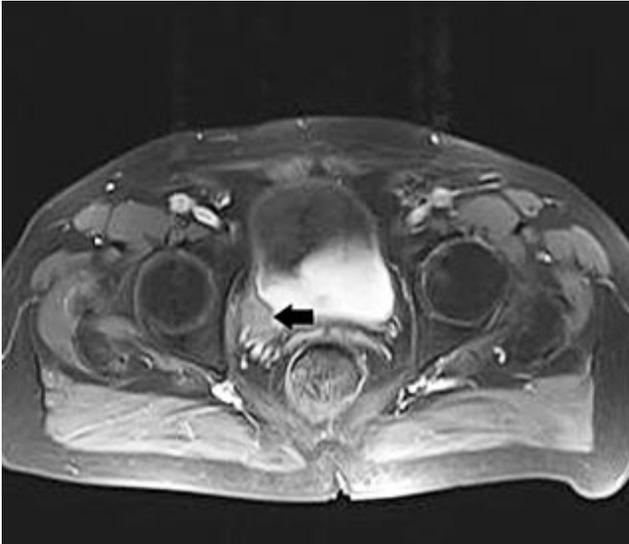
Axial plane T1 Weighted MRI images obtained after intravenous contrast media administration shows small amount contrast enhancement of the intradiverticular tumor (arrow).
